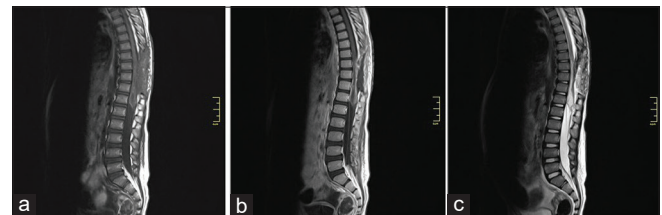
T1-weighted magnetic resonance image with/without contrast (a and b), and T2-weighted magnetic resonance image (c) showing spinal cord abscess appeared following the first operation
